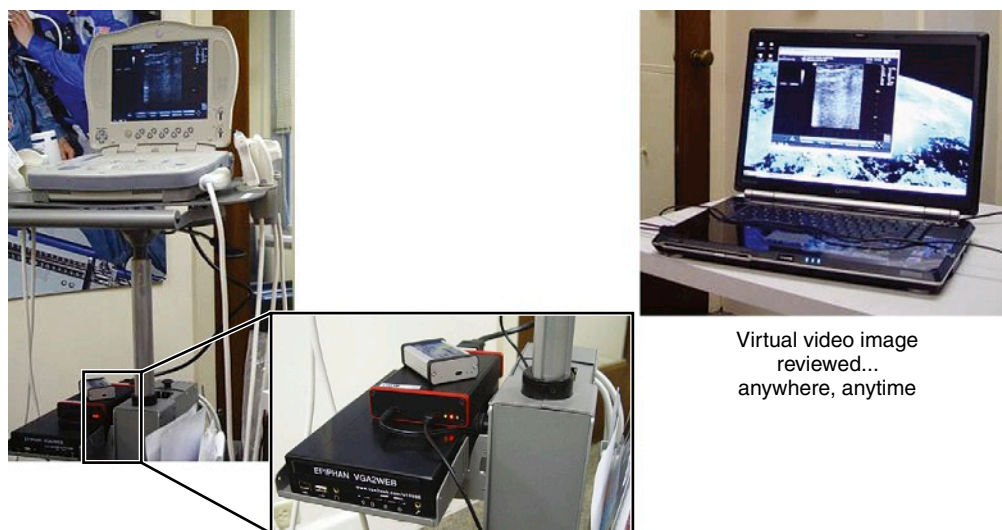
Distant Doctor unit, a Web-enabled image-capture device used to transmit ultrasound images and video remotely.
